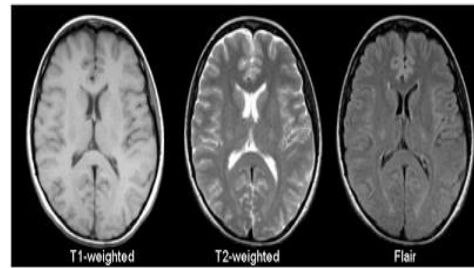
(a) T1- weighted (b) T2- weighted (c) FLAIR
